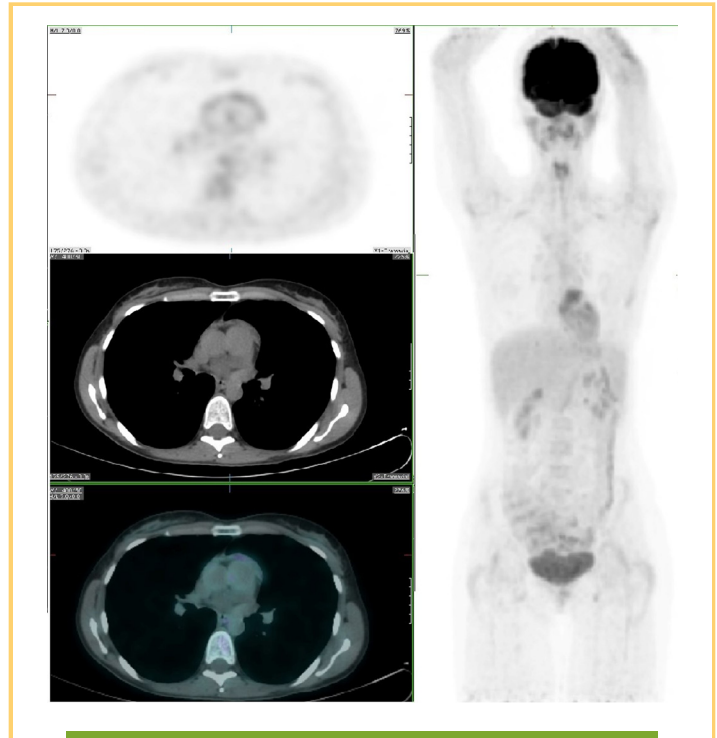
MIP and axial PET, CT, and fused PET/CT images of the progress PET/CT 8 months following diagnosis confirmed complete resolution of the widespread lymph node uptake with virtual complete metabolic response in all the nodal stations, spleen, and the skeleton.
